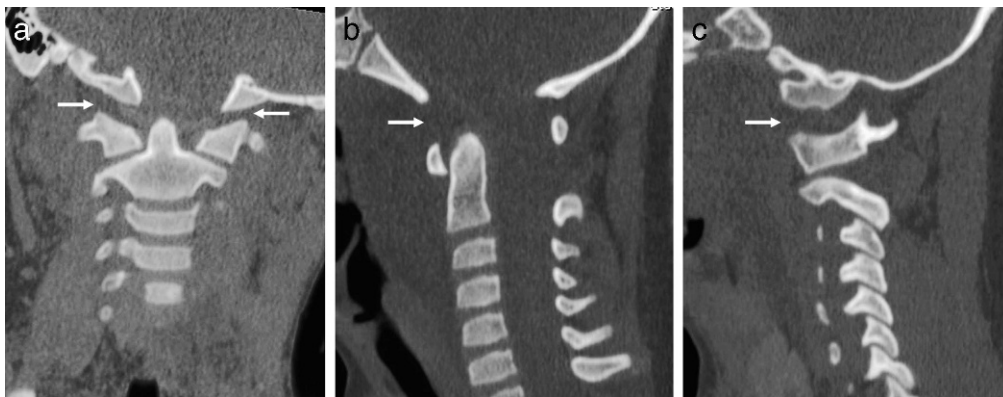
Atlanto-occipital distraction injury. (a) Coronal CT show marked widening of the atlanto-occipital space in a child (arrow). (b) Sagittal CT shows the widened atlanto-occipital interval (arrow). (c) Parasagittal CT shows the widened atlanto-occipital interval (arrow).
